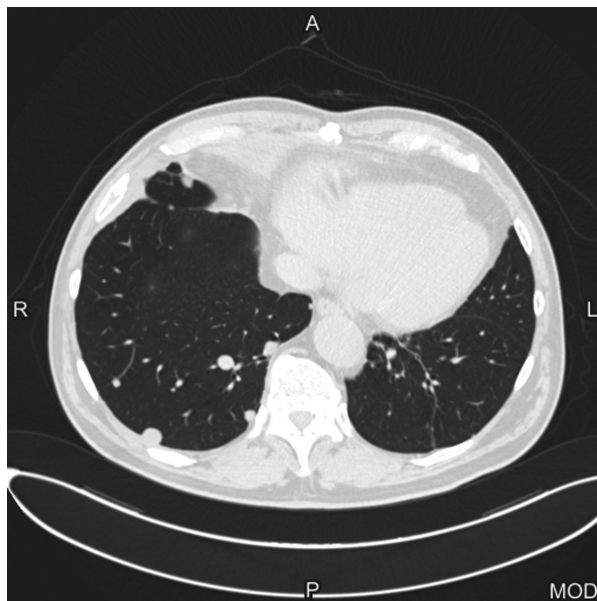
CT scan of the chest in August 2012 showing multiple pulmonary nodules unchanged for about 4 years
